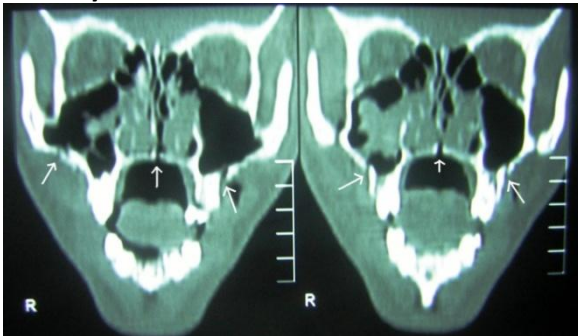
Preoperative CT Axial section- Arrows showing fractures and hematoma collection in antrum
